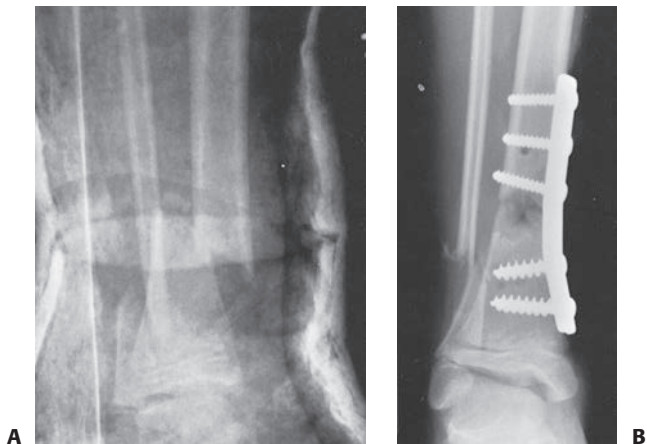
A: Anteroposterior radiograph of a distal one-third tibial and fibular fractures in a 9-year-old girl with a closed head injury and severe spasticity. The initial reduction in a cast could not be maintained. B: Open reduction and internal fixation with a medial buttress plate was used to achieve and maintain the alignment.
